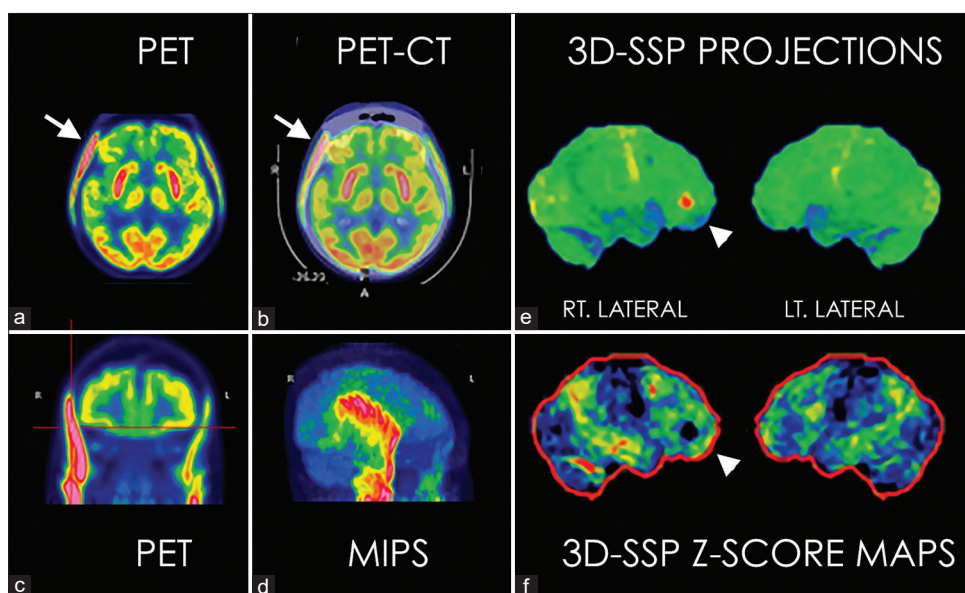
The transaxial (^{18}F) fluorodeoxyglucose brain positron emission tomography images (a) showed hypometabolism in bilateral frontal and temporal lobes and diffuse extracranial fluorodeoxyglucose uptake corresponding to temporal and masseter muscles bilaterally on the fused positron emission tomography/computed tomography (b) Coronal positron emission tomography (c) and maximum-intensity projection (d) confirmed extracranial uptake to be in temporal muscle, which fused with cortical uptake in the right frontal lobe (arrow, a and b) resulted in an unusual focal “hot spot” artifact in the right frontal lobe on the three-dimensional stereotactic surface projections projection image (arrowhead, e) and a round “defect” on the three-dimensional stereotactic surface projections Z-score map image (arrowhead, f)
